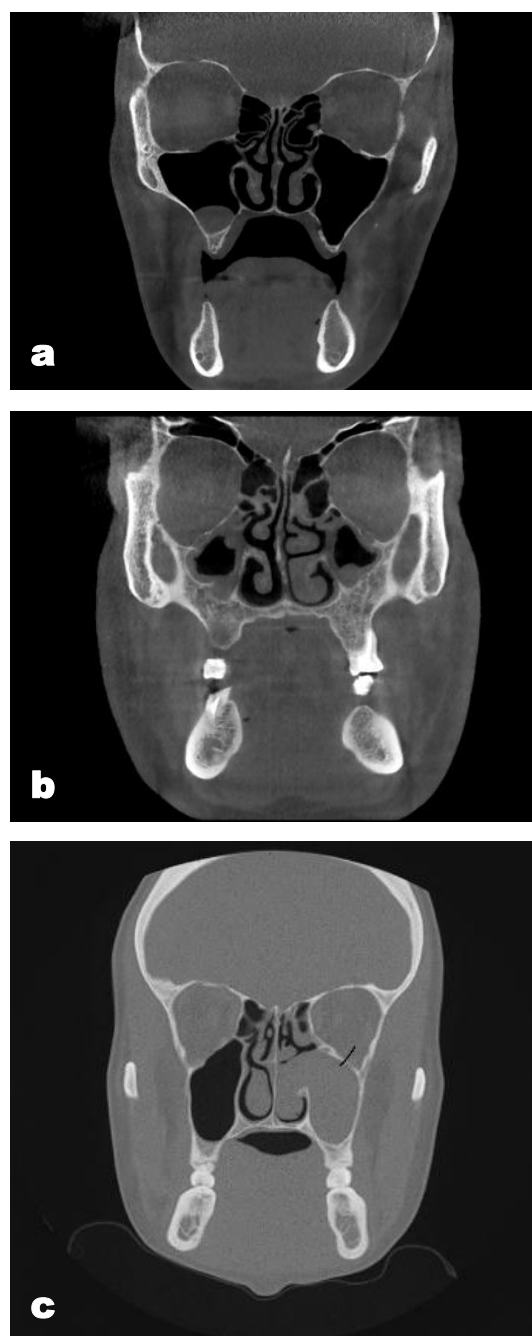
Mucous retention cyst (a), mucosal thickening (b), and sinus polyp (c) in maxillary sinuses on coronal CBCT images
